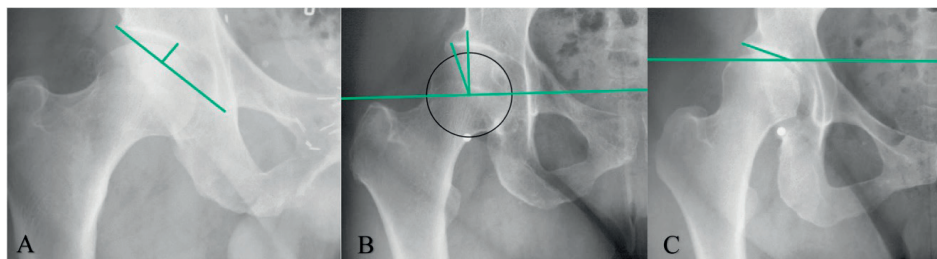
Anteroposterior in pelvic radiographs with three radiographic measurements to define AD. A: The acetabular depth-width ratio (ADR): The acetabular width was defined as a line across the length of the acetabular opening, extending from the lateral edge of the acetabulum to the pelvic teardrop. Next, the acetabular depth was determined by constructing a line perpendicular to the acetabular width, extending from the most medial point of the sourcil. The ADR is defined as the ratio of the depth to the width, multiplied by 1000. B: The Center Edge Angle of Wiberg (WCEA): To determine the center of the femoral head, a best-fitting circle is outlined around the femoral head based on the SSM points. The WCEA is then formed by a line drawn vertically through the center of the femoral head, perpendicular to the horizontal reference line, the second is drawn from the center of the femoral head to the most lateral weight-bearing part of the sourcil. C: The modified acetabular index (mAI): The mAI measures the acetabular roof inclination. The measure is modified, as the original acetabular index is applied to hips with an open triradiate cartilage. The mAI measures inclination from the medial sourcil to the lateral bony part of the acetabulum. Horizontal reference line (B+C): To correct for pelvic rotation, a horizontal reference line is calculated based on the average of 4 lines, between 1) both femoral head centers, 2) the most cranial points of the foramen obturator, 3) the most caudal points of the ischial tuberosity and 4) the most caudal points of the pelvic teardrop.
